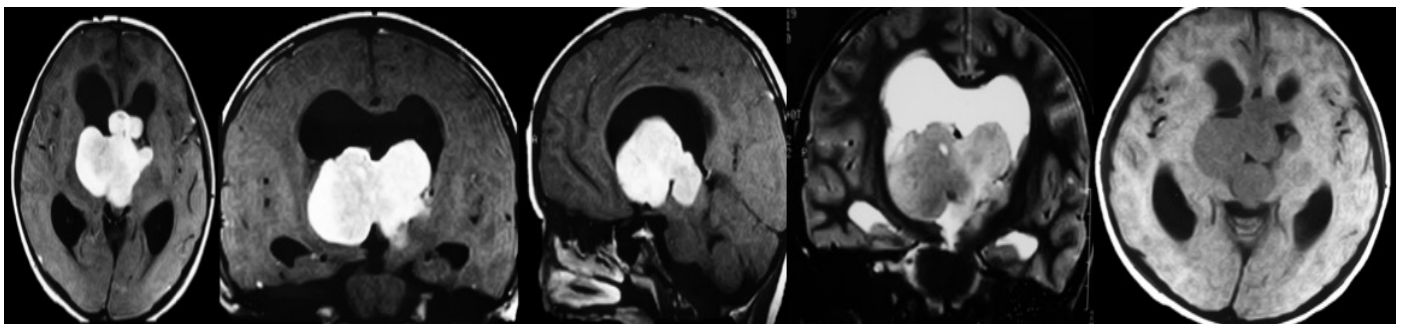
MRI study of Case 1; preoperative axial, coronal and sagittal T1W images showing homogenous enhancement after gadolinium injection. Coronal T2W and axial flair images show no periventricular passage of cerebrospinal fluid(CSF) despite prominent hydrocephalus.
